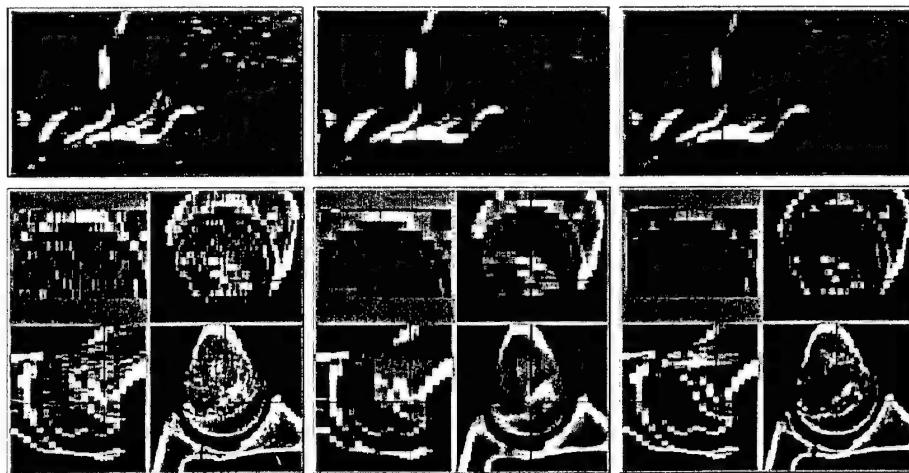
Top row shows data from phase contrast MRA and bottom row shows CT data of a femoral joint. The original data (left) was restored using both anisotropic diffusion (middle) and anisotropic adaptive filtering (right).
